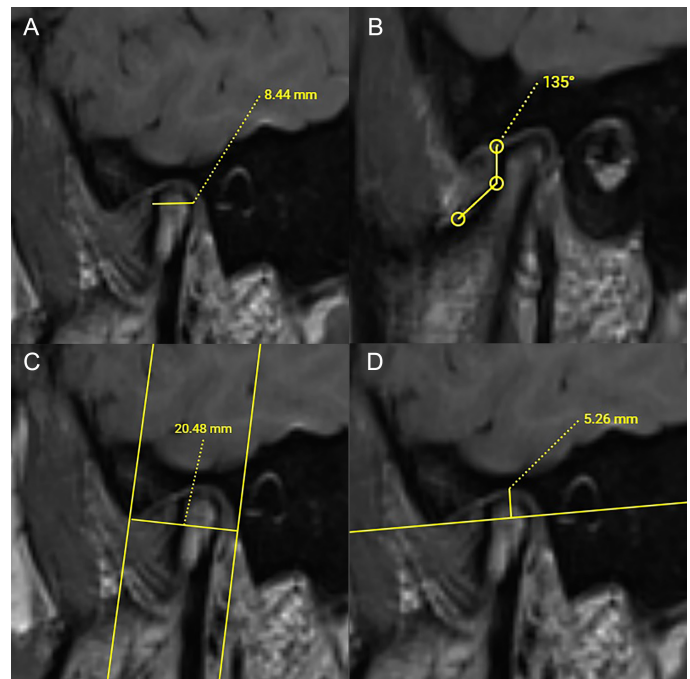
Measurement technique of the morphological parameters. The interval between the most anterior and posterior edges of the mandibular condyle as APLENGTHCo (A). ACoA was measured from the anterior edge, as the angle formed between the head and the neck of the mandibular condyle (B). GFW was determined as the distance between the post-glenoid process and the vertex of the joint eminence (C). The interval between the highest point of the fossa and the line between the post-glenoid process and the articular eminence vertex was considered as GFD (D). All measurements were performed on the sagittal MR images.
